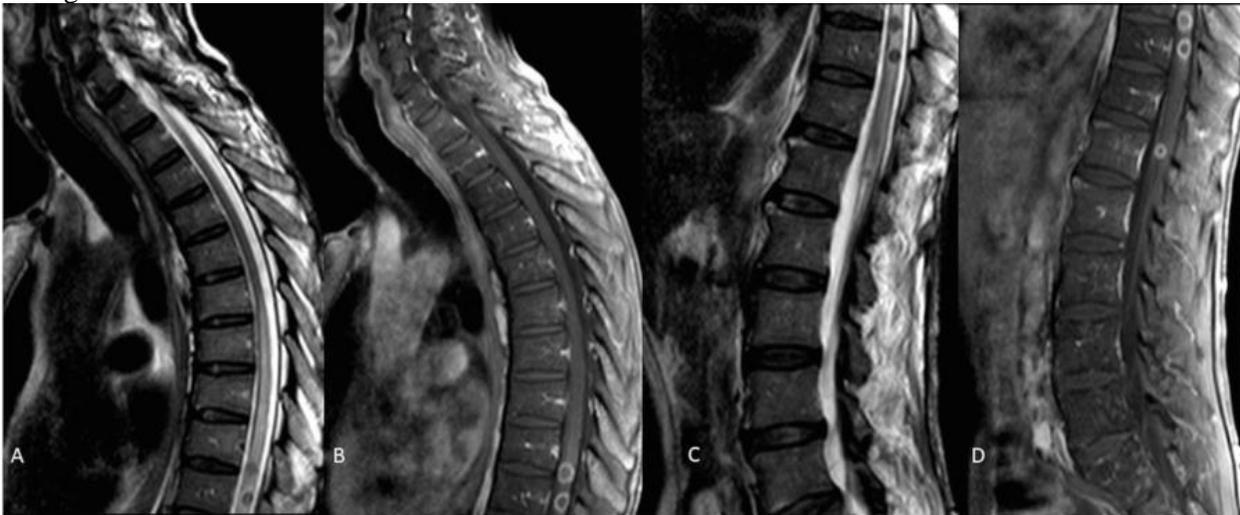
Male, 62 years old, gardener, with lower limb paresthesia, muscle weakness, urinary and bowel incontinence and skin lesions. The skin biopsy shows *Paracoccidioides brasiliensis*. The spine MRI shows intramedullary nodular lesions at T10-11 level with hyposignal on T2 weighted sequences (A) and peripheral enhancement after paramagnetic contrast administration (B). More intramedullary lesions can be seen in lumbar spine with hyposignal on T2 (C) and peripheral enhancement after paramagnetic contrast administration (D). There is hyperintense signal on T2 weighted images at adjacent medular spine (A).
